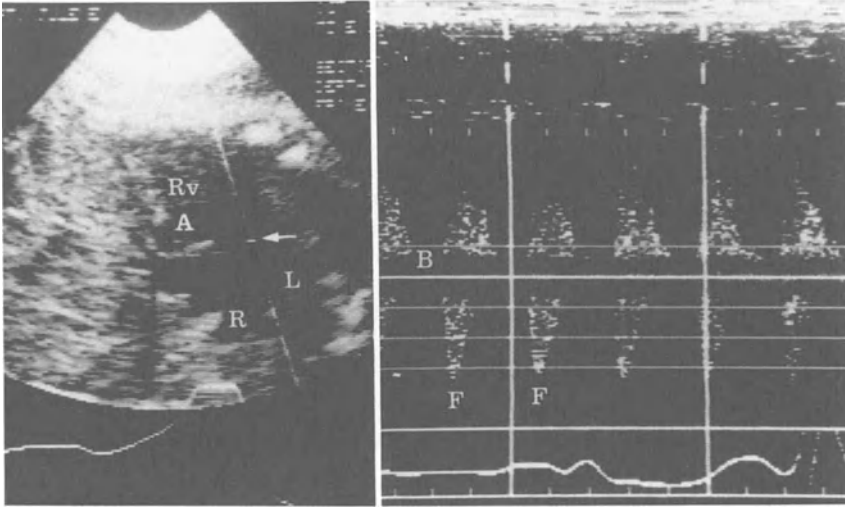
Fetal Doppler echocardiographic examination in tetralogy of Fallot and aneurysmal dilatation of the main pulmonary artery. The large echo-free space present on the left of the aorta on real-time two-dimensional examination (A) was demonstrated by pulsed Doppler to be vascular in nature, because pulsatile flow (B) similar to that obtained in the pulmonary artery could be demonstrated within it (B). This Doppler finding helped us make a confident diagnosis of aneurysmal dilatation of the main pulmonary artery. The arrow denotes the location of the Doppler sample volume. (A, aorta; B, Doppler baseline; F, Doppler waveforms; L, left branch of the pulmonary artery; R, right branch of the pulmonary artery; RV, right ventricle.) (Source: Reprinted with permission from Maulik D, Nanda NC, Saini VD, Thiede HA. Application of Doppler echocardiography in the assessment of fetal cardiac disease. *Am J Obstet Gynecol.* 1985;151:951-956.)
